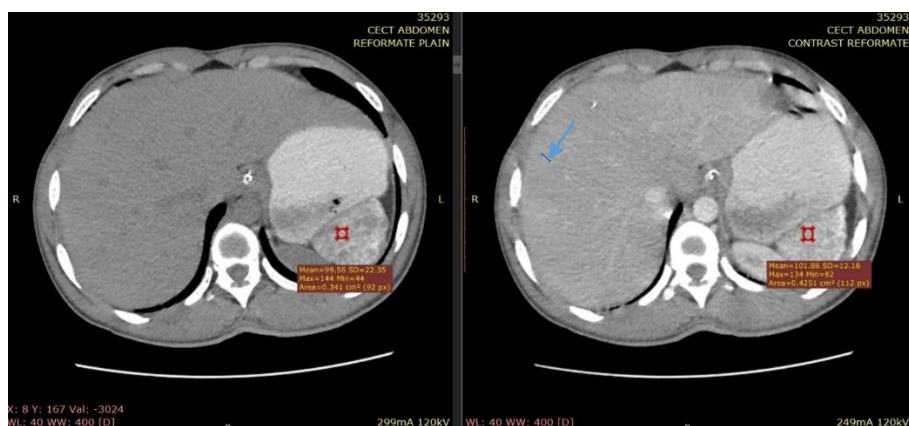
CT abdomen (Axial section) pre contrast and post contrast images showing shrunken spleen with no significant post contrast enhancement
